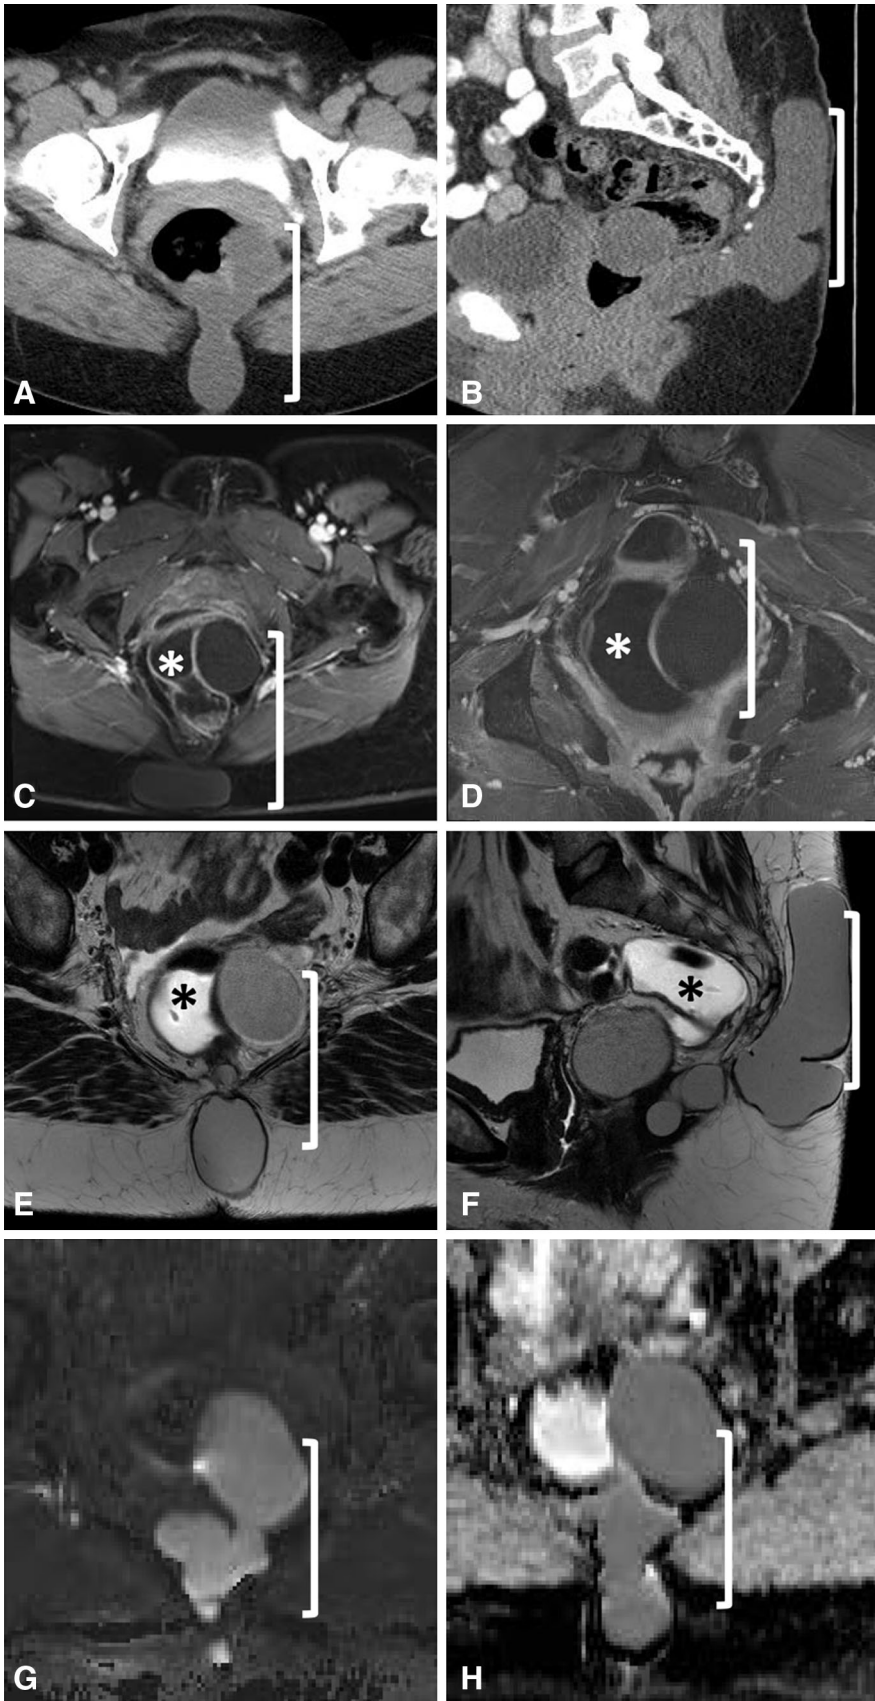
Surgically proven epidermoid cyst. A Axial CECT shows a non-enhancing perirectal cystic lesion (bracketed). B Sagittal CECT demonstrates posterior subcutaneous extension of this lesion. C Axial and D coronal fat-sat T1-weighted post-contrast MRI shows a non-enhancing low T1 signal lesion. The mass results in compression of the gel-filled rectum (asterisk). This lobular but unilocular lesion shows intermediate signal on E axial and F sagittal T2-weighted images. Minimal restricted diffusion on G high B value and H ADC images.
